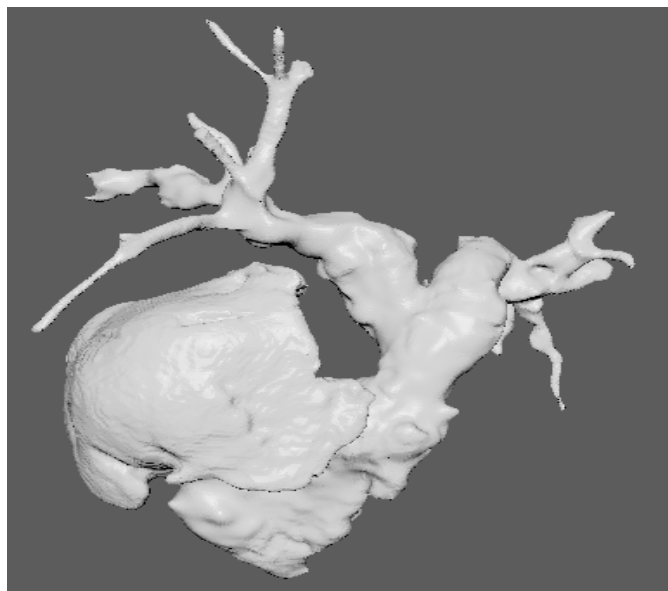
The initial model after the segmentation of the CT scan provided for patient 1.
